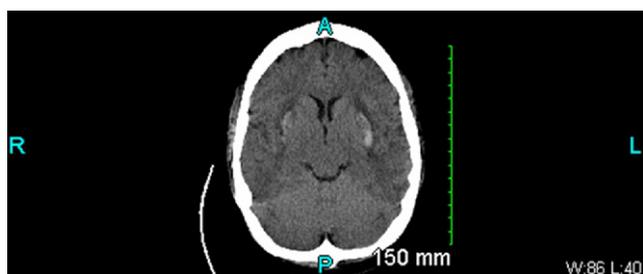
Contrast computed tomography scan of the head demonstrating evolving hypoattenuation within the bilateral putaminal regions. No midline shift is visible.
